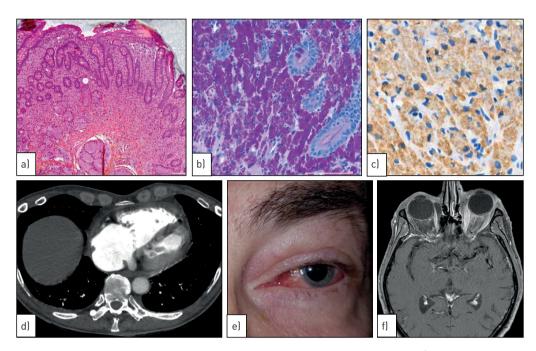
Main characteristics of the patient at the diagnosis of Whipple's disease. a) Diffuse and massive infiltration of the lamina propria by foamy and pink macrophages (haemotoxylin, eosin and safran, original magnification ×100). b) Periodic acid-Schiff-positive macrophages with round bacterial inclusions in the lamina propria (original magnification ×200). c) CD68-positive macrophages in the lamina propria (Agilent, clone PG-M1 1/200, original magnification ×200). d) Axial contrast-enhanced high-resolution computed tomography image of the mediastinum showing right atrium and ventricle dilation. e) Photograph showing the left congestive eye associated with proptosis, periorbital inflammation and lateral deviation. f) Orbital magnetic resonance imagery in T2-weighted imaging showing left exophthalmia and a hypersignal of the left orbit consistent with an inflammatory pseudo-tumour.
